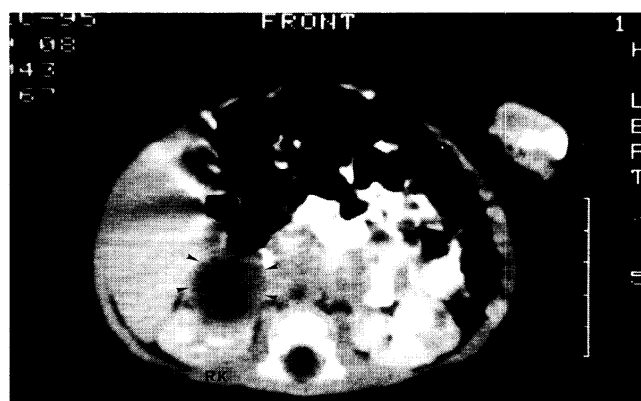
Neonatal CT scan with contrast enhancement at age 6 weeks, demonstrating a well-defined hypodense nodular lesion (arrowheads) over the upper pole of the right kidney
